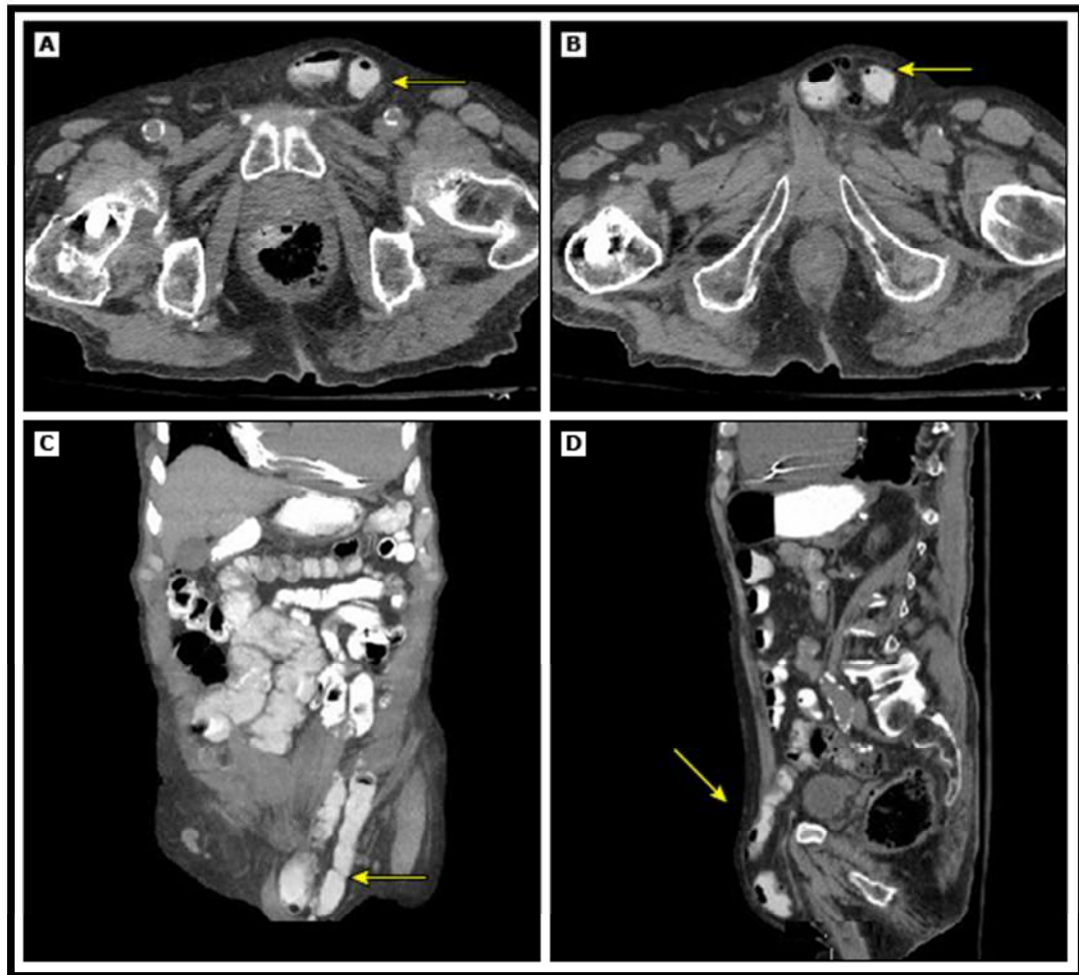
Left inguinal hernia-non-obstructing on CT and position of pubic tubercle
